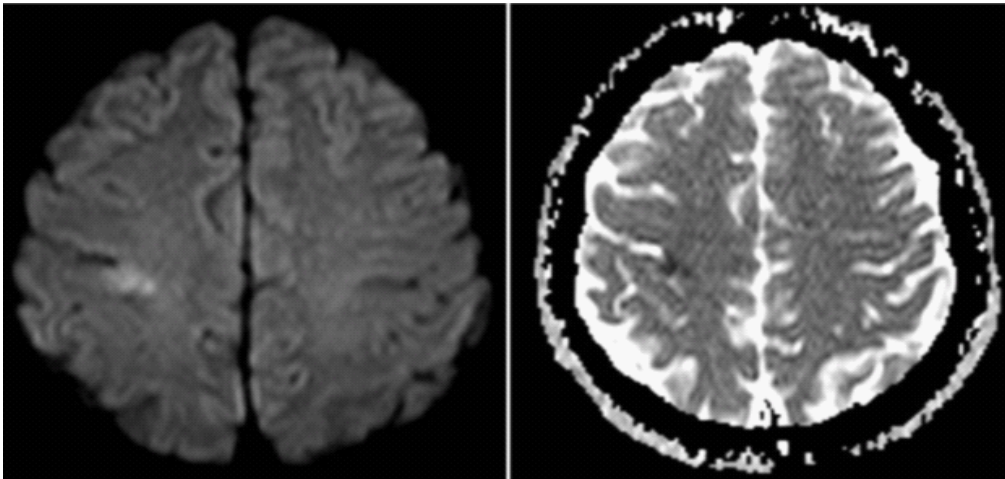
Axial cuts of cranial MRI without contrast showing an area of restricted diffusion on DWI with corresponding signal drop on ADC at the right frontal lobe.
